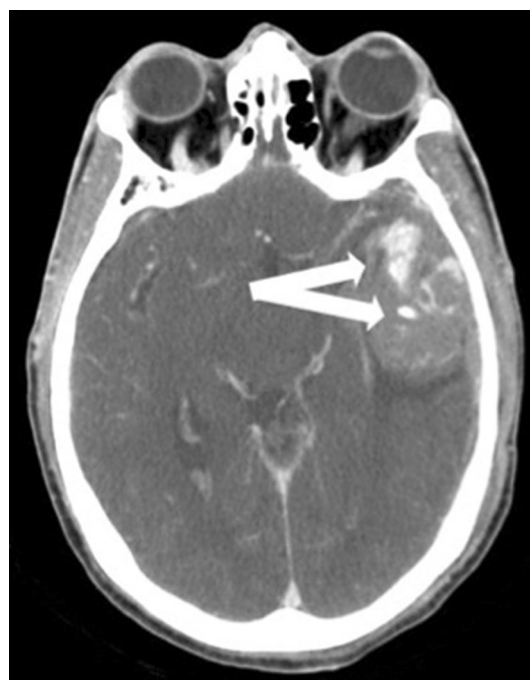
Contrast extravasation (“Spot Sign”) in acute ICH. In this post-contrast image obtained after administration of IV contrast during a “code stroke” CT (non-contrast study, CT angiogram, CT perfusion study), contrast extravasation is present in this acute *left temporal lobe* ICH. This finding is commonly referred to as a “spot sign” (arrows) and is associated with increased risk of hematoma expansion
